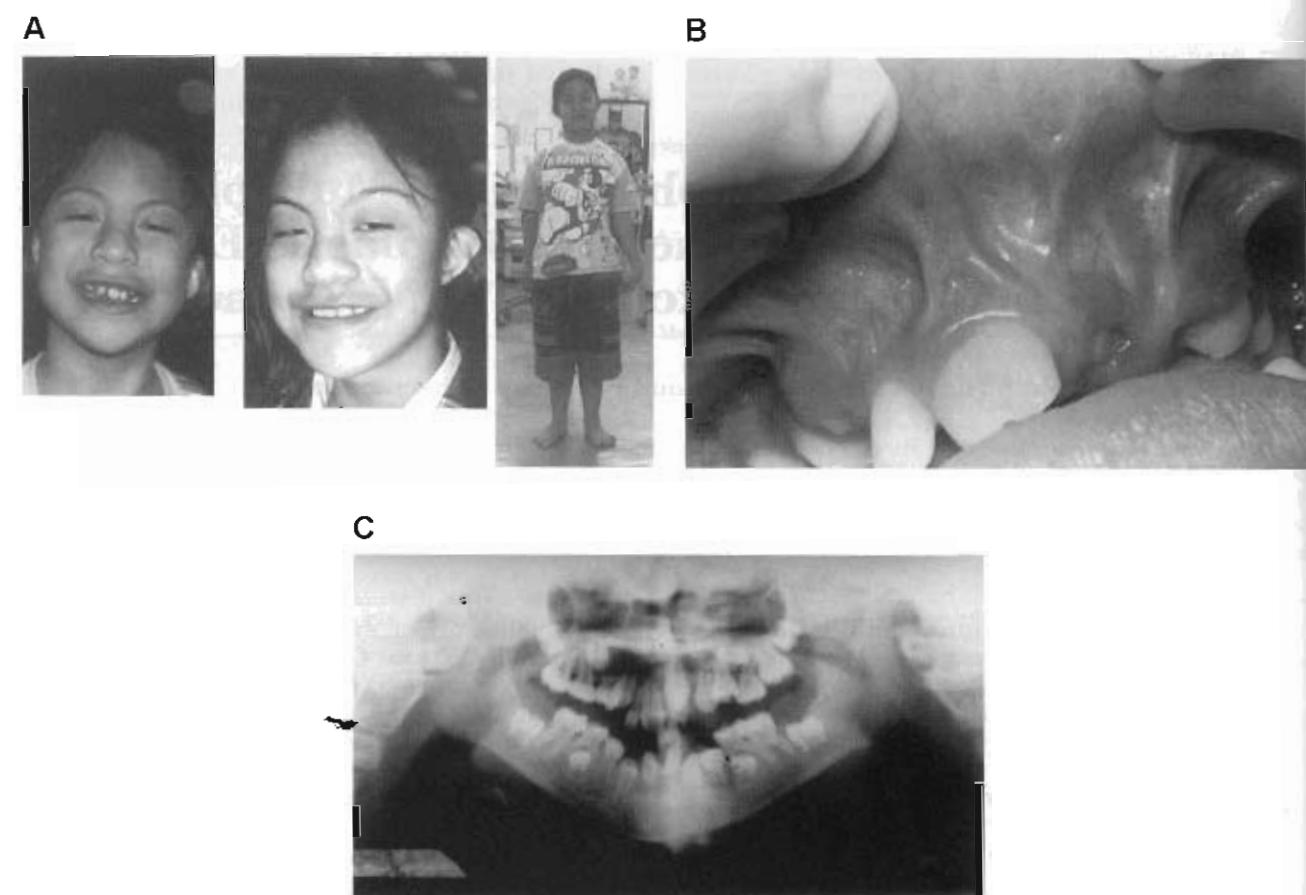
A: Patient at the ages of 8, 11, and 12 years. B: Large maxillary permanent central incisor. Multiple, hyperplastic frenula. C: Panoramic radiograph at the age of 8 years showed hypodontia, short-rooted incisors, and premolars.
